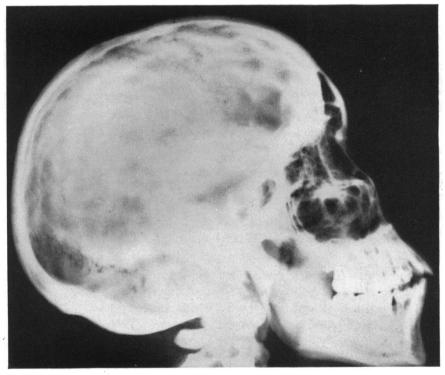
Roentgenogram of the skull showing a marked increase in digital impressions, calcification of the pineal body, and a normal sella turcica.
